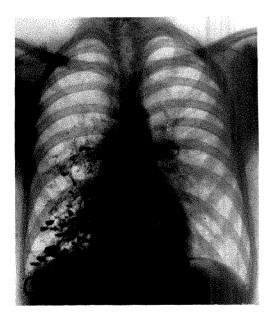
Case II. Uncomplicated cystic bronchiectasis. Recatgenogram of September, 1929 (A) shows whereous thin-walled annular formations of our pying the lower two-thirds of the right lung Roentgenogram (B) taken in 1938, nine recast later, shows multiple small fluid levels which the cavities, otherwise no essential change. Seenchogram (C) demonstrates many saccalar and cylindrical dilatations of the broach in the right middle and lower lobes.
